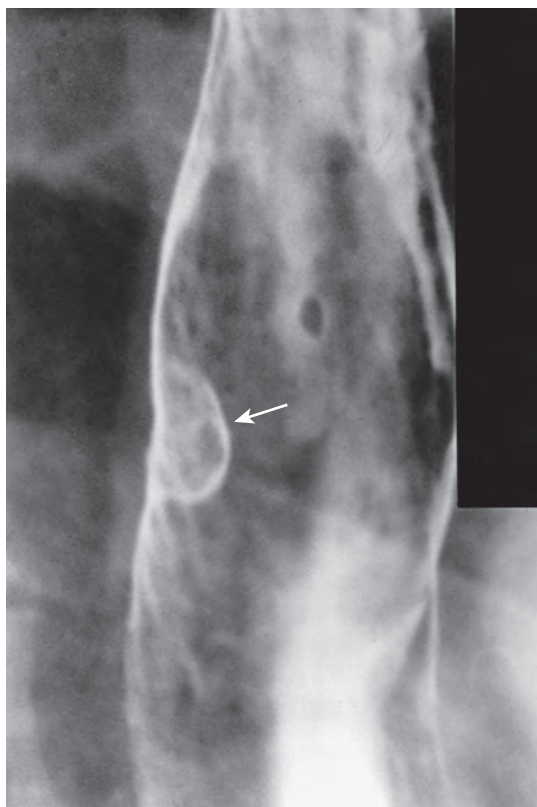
Early esophageal cancer. The lesion appears radiographically as a small sessile polyp (arrow) in the midesophagus. A benign squamous papilloma could produce a similar appearance. (Courtesy Seth N. Glick, MD, Philadelphia.)
